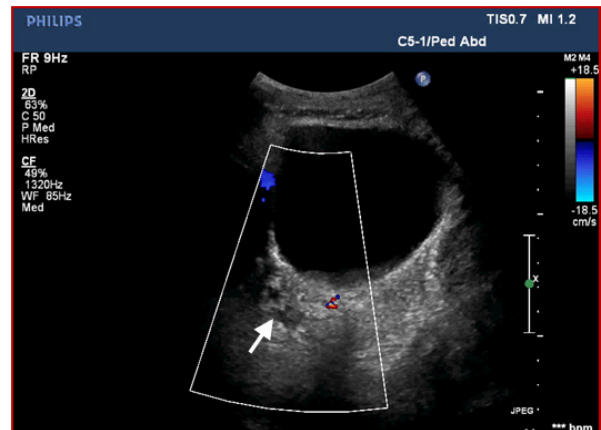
Postoperative Doppler ultrasound scan of the left ovary (white arrow) in a premenarchal patient with a left ovary with visible blood flow after a third torsion and a second oophorectomy
